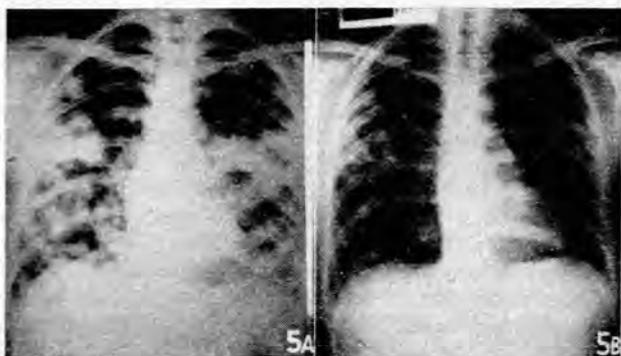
X-ray of chest before treatment.
